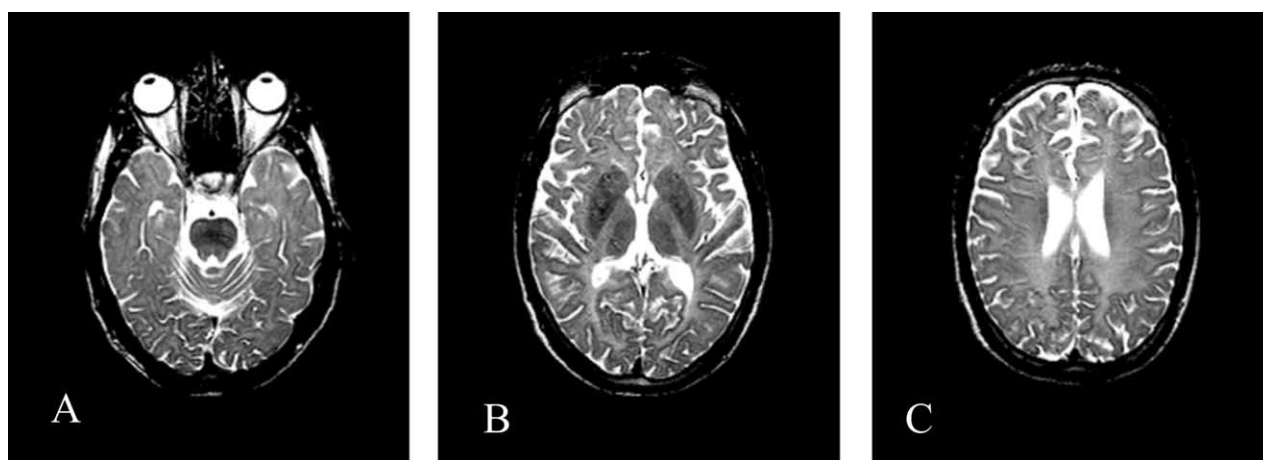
MRI scans of the patient at the age of 24 years. Axial, 5 mm thick, T2-weighted fast spin echo images (A) at the level of the mesencephalon, (B) basal ganglia, and (C) at the roofs of the lateral ventricles. Although disturbed by motion artifacts, increased signal intensity of the white matter suggestive of lack of myelination is clearly visible. Note that both mesencephalon and globus pallidus have low signal intensity indicating that some myelin is preserved within these structures.
